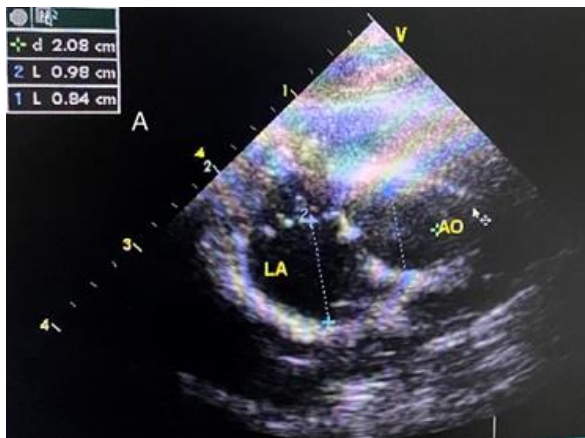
B-mode echocardiographic indices in right parasternal (A) measuring LA/Ao at the point of maximal LA size in short axis view in which in this case it is 1.16 (B) Assessing the defect size between right and left atria in long axis in which in this case it is 2.7mm
